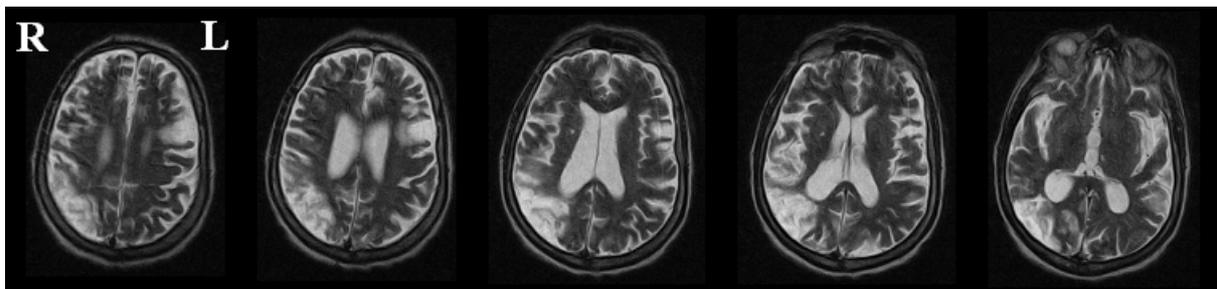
Patient FC's MRI showing a right ischemic stroke in the parieto-occipital junction area.
